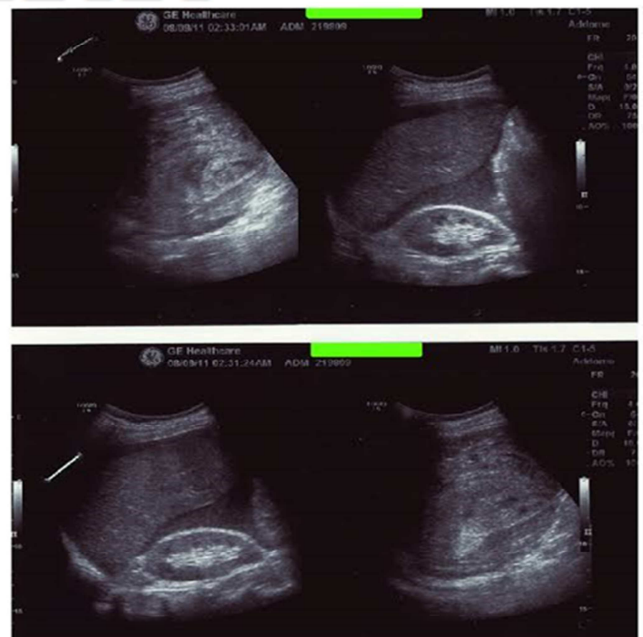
Abdominal Ultrasonography shoing the spleen rupture with hemoperitoneum.
